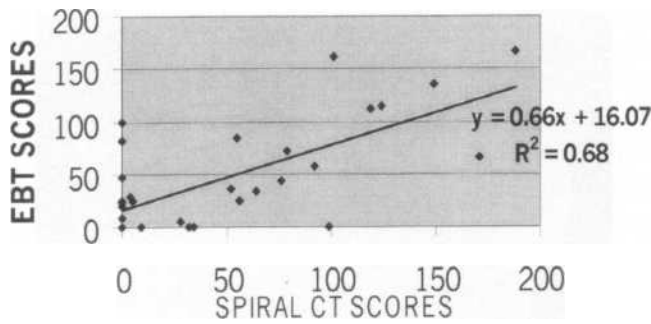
A linear regression comparing electron beam tomography scores against the spiral CT scores in the same patients. CT=Computed Tomography; EBT=Electron Beam Tomography.
